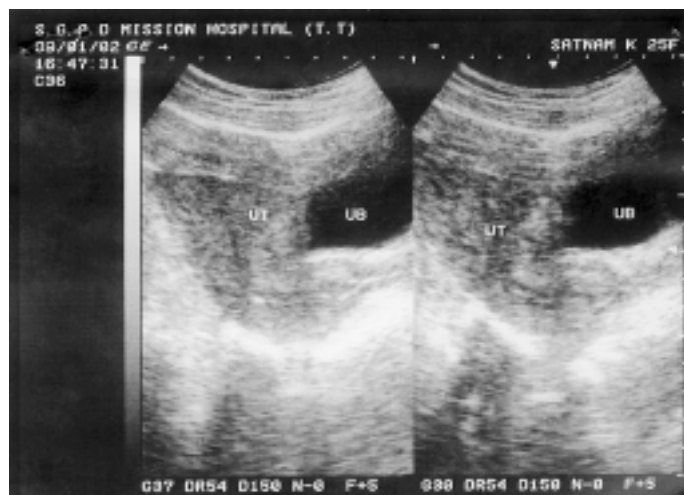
Sonography showing normal uterine cavity.
